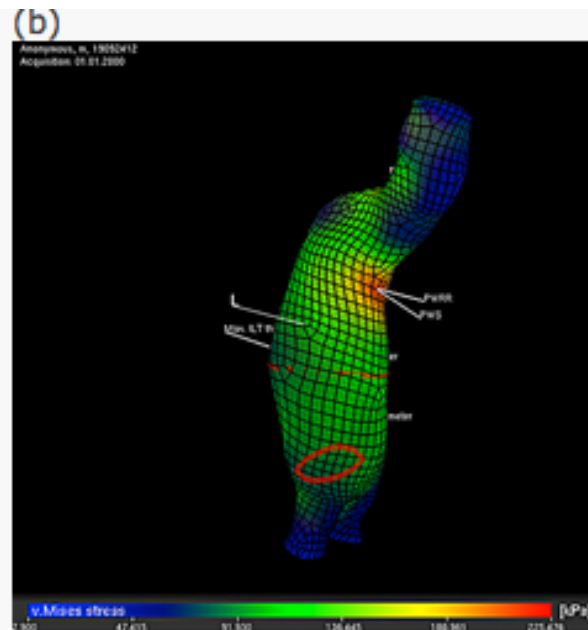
Clinical case I. (a) CT slice at the largest diameter of 5.2cm. (b) Wall stress distribution. (c) A4clinics summary with highlighted A4PWRR. (d) Rupture risk equivalent diameter of 4.6 cm.
